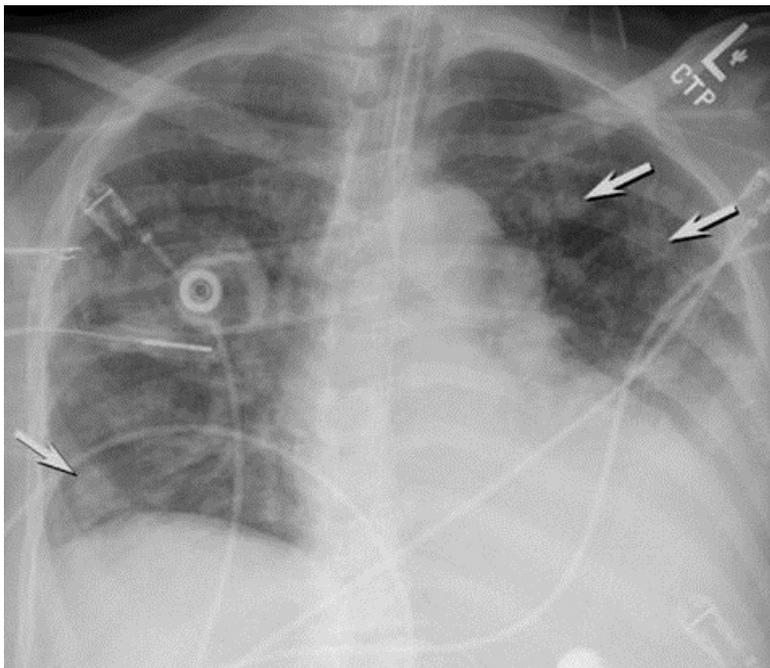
Frontal chest radiography shows continued lingular and left lower lobe consolidation, with left pleural liquid, now with development of multiple, vague, poorly defined nodular opacities (arrows) bilaterally. The patient is now intubated.
